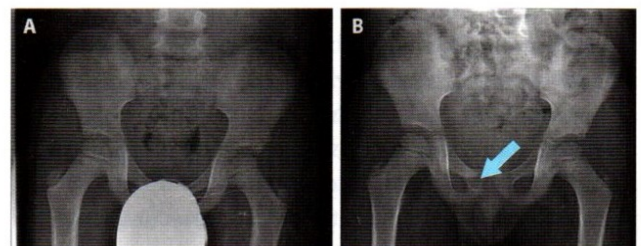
Pelvic radiograph demonstrating a lead shield obstructing pathology (A). The pathology is visible once the shield is removed (B). Reprinted under the Creative Commons Attribution 2.0 Generic license. Frantzen MJ, Robben S, Postma AA, et al. Gonad shielding in paediatric pelvic radiography: disadvantages prevail over benefit. *Insights Imaging*. 2012;3:23-32. doi:10.1007/s13244-011-0130-3. creativecommons.org/licenses/by/2.0/
